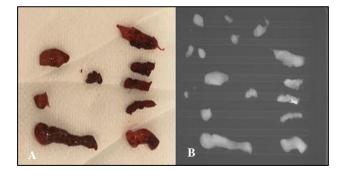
(A & B): Removed tissue with pads and marker along with corresponding X-ray.
